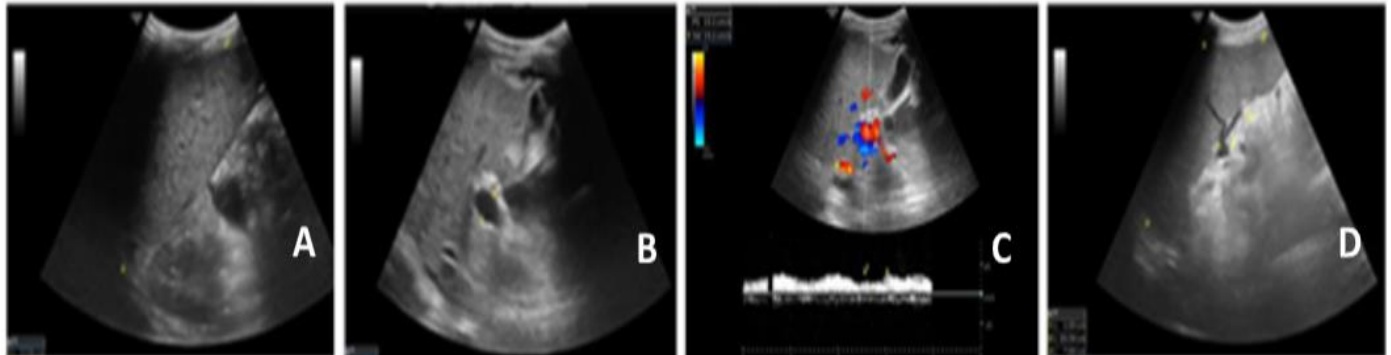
(A-D): A male patient 55 year old presented with grade III EV post DAAS therapy with platelet count 86000 n/u.l. Abdominal ultrasonography reveals cirrhotic liver with liver span 13 cm (A), PV diameter 14.5mm (B), PVV 15.1cm/sec (C), longitudinal and transverse splenic diameters 20.39cm and 7.69cm. $SI=20.39 \times 7.69=156.79$, $SPI=156.79/15.1=10.38$, $PCSDR = 86000/203.9=421.77$
